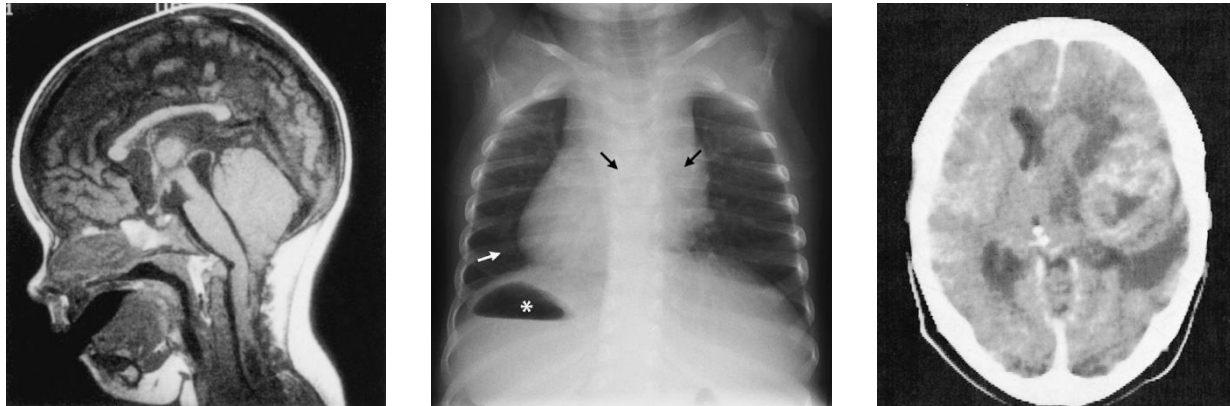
Sagittal plane (MRI, head), frontal plane (X-ray, chest), and transverse plane (CT, brain)
